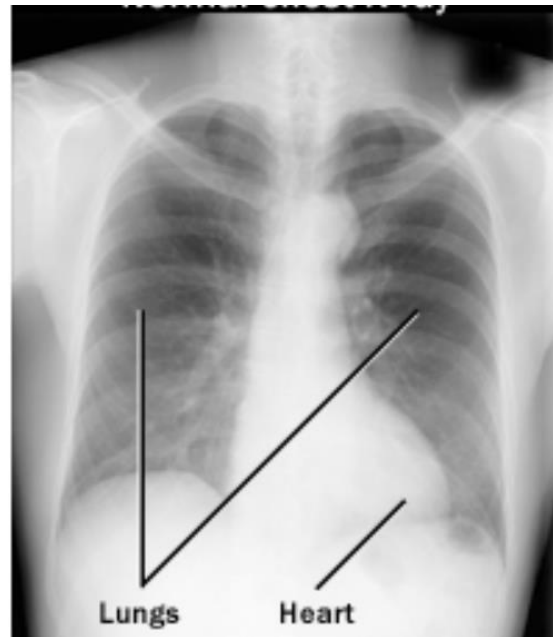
Chest xray. The radiologist interpreted the chest xray as normal with no acute findings.
